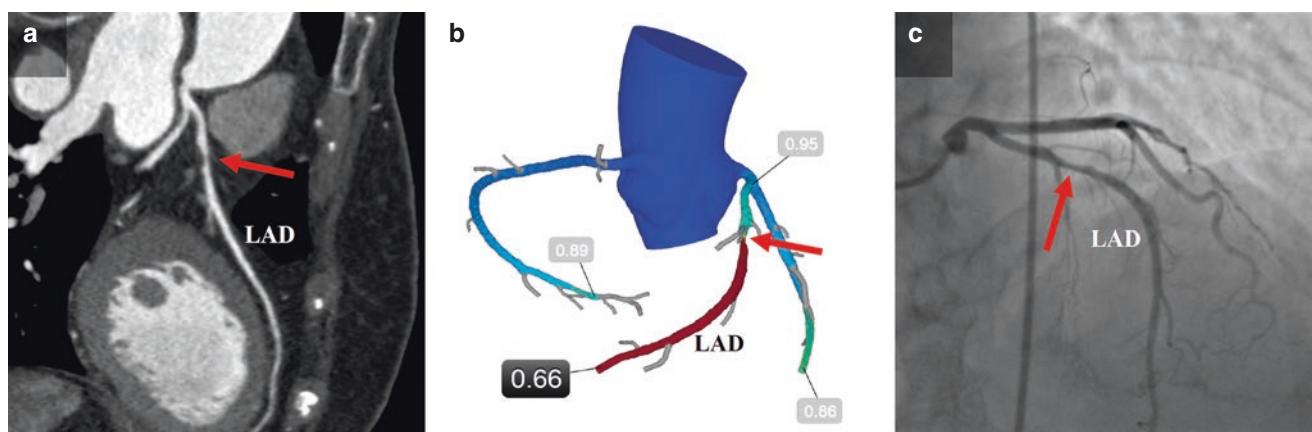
Example of high-grade stenosis (red arrow) in left anterior descending. (a) Curved multiplanar reconstruction of the LAD. (b) CT-based virtual quantification of fractional flow reserve (CT-FFR).
